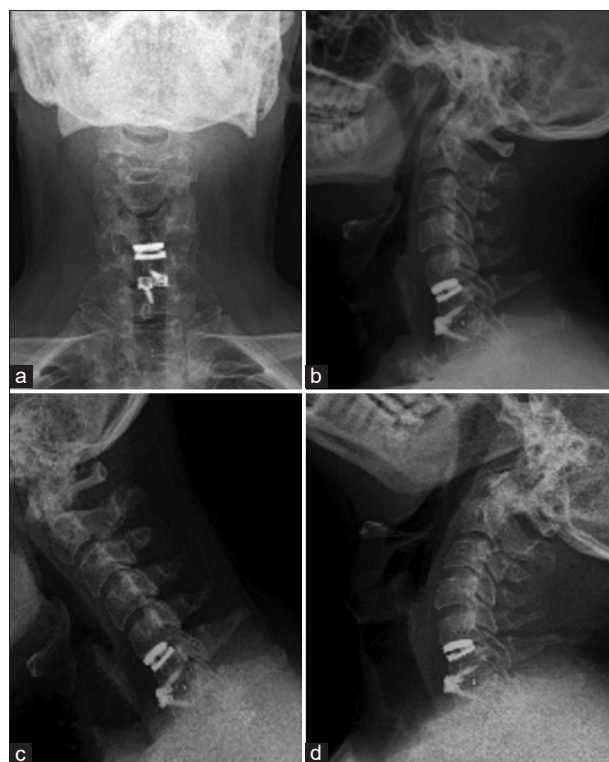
Postoperative X-ray of patient with hybrid fixation- anterior-posterior view (a), lateral view – neutral (b), lateral view – flexion (c), lateral view – extension (d)
